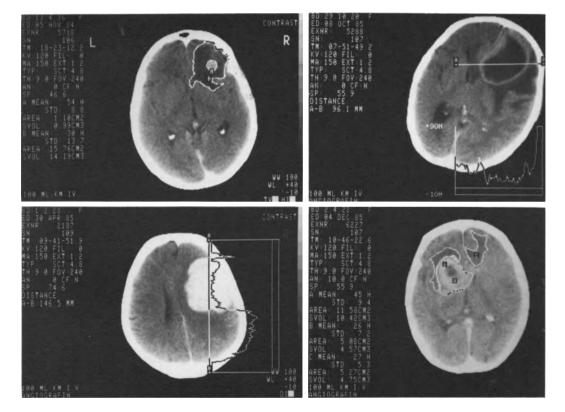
Planimetric measurement of brain edema and tumor in cranial CT. Top left: metastasis; top right: low-grade glioma; bottom left: meningioma; bottom right: malignant glioma
